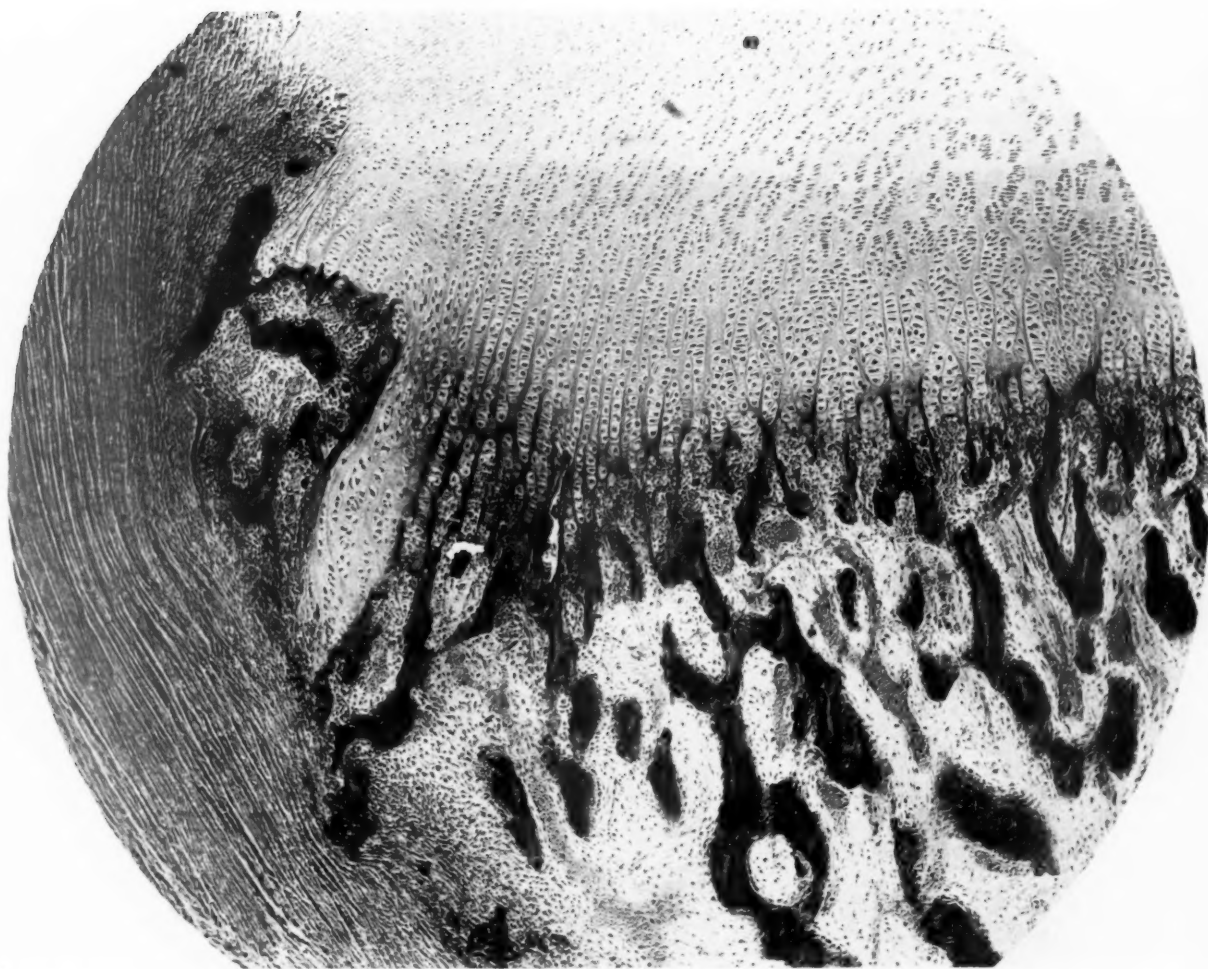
M. B., 24. Microphotograph of inner corner of lower end of femur from fig. 22, showing extensive destruction of the cortex and adjacent lattice. A lattice has started to form at the side of the proliferative cartilage, separated from the rest by a tongue of the latter which extends downwards almost to the periosteum. Rarefaction is rampant in this island of lattice separated by the tongue. If this island of lattice were only larger, it might give rise in the x-ray picture to the appearance of 'over-extension and pointing' of the corner of the end of the shaft.
